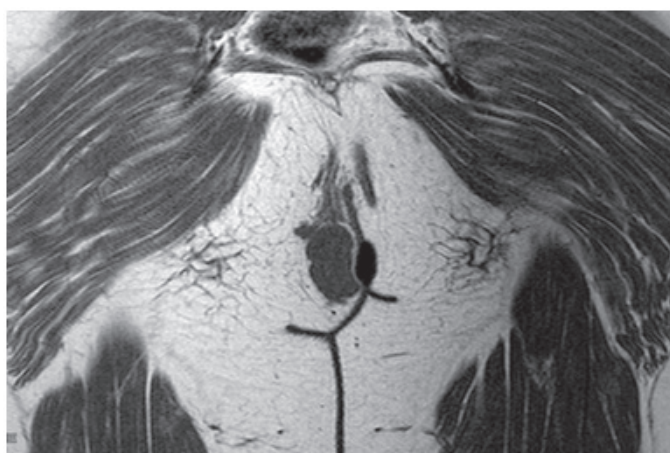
Preoperative Magnetic Resonance Image: a solid non-specific ovoid mass in the subcutaneous tissue, measuring 67 mm in its longer axis.
